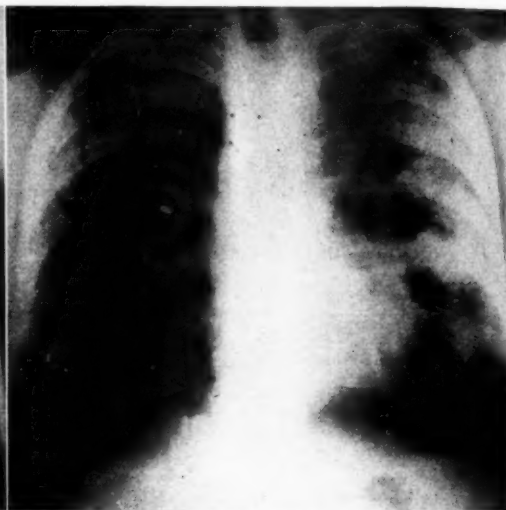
Roentgenogram of the chest of a man of forty-eight years suffering from pneumoconiosis.
